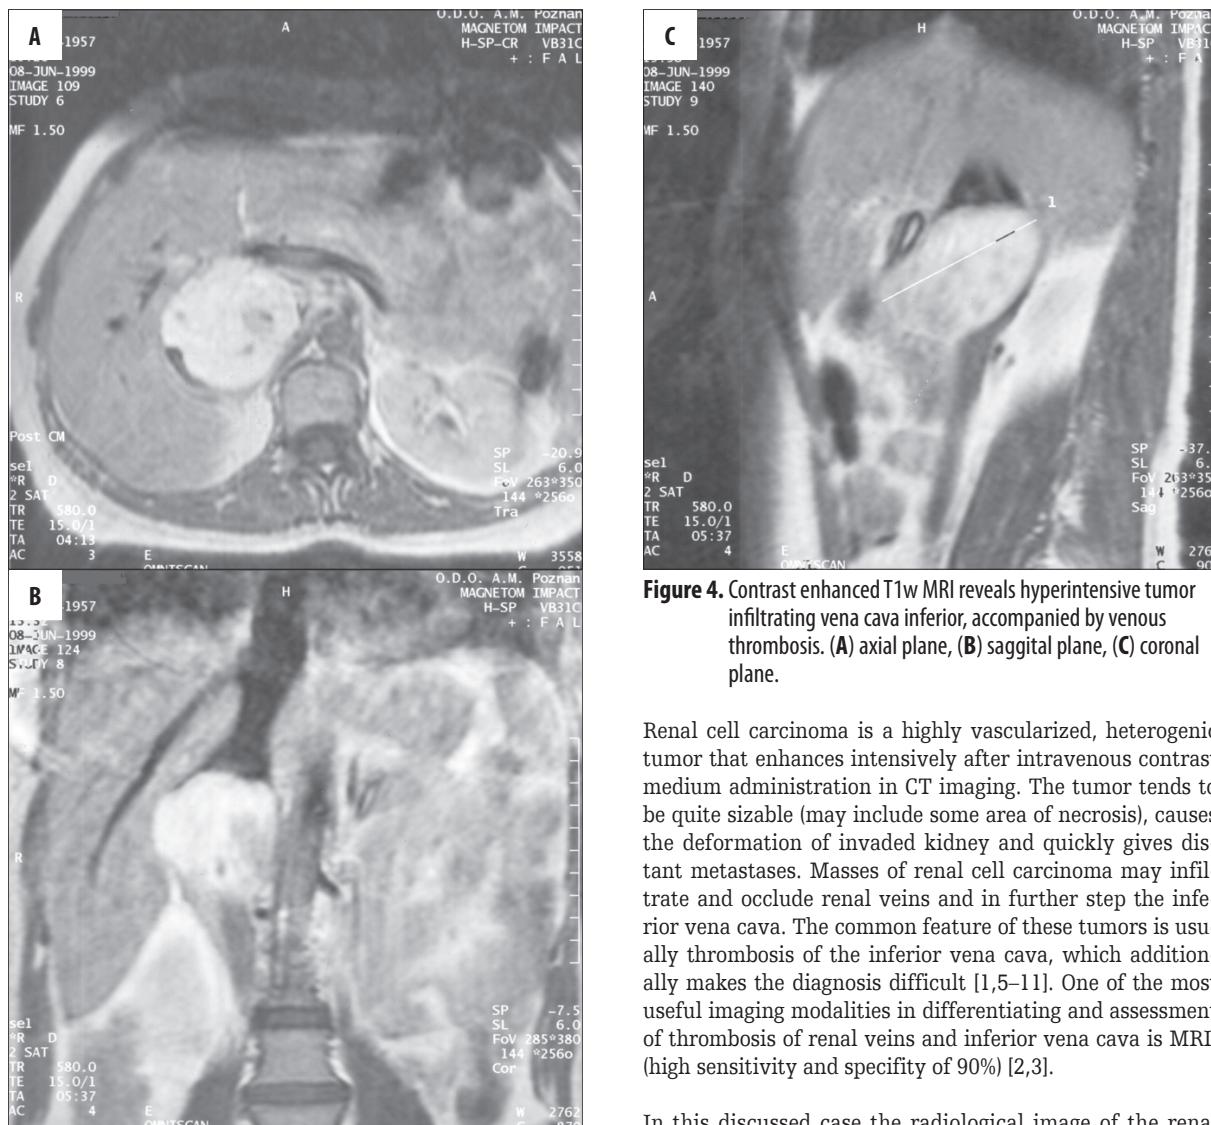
Contrast enhanced T1w MRI reveals hyperintensive tumor infiltrating vena cava inferior, accompanied by venous thrombosis. (A) axial plane, (B) sagittal plane, (C) coronal plane.
